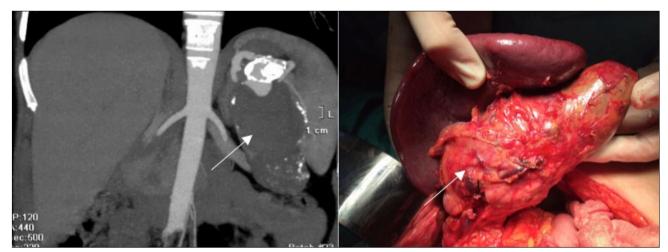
(a) CT image of a giant splenic artery aneurysm (SAA) (b) Intraoperative findings – aneurysmectomy with splenectomy. Arrows point to SAA.
